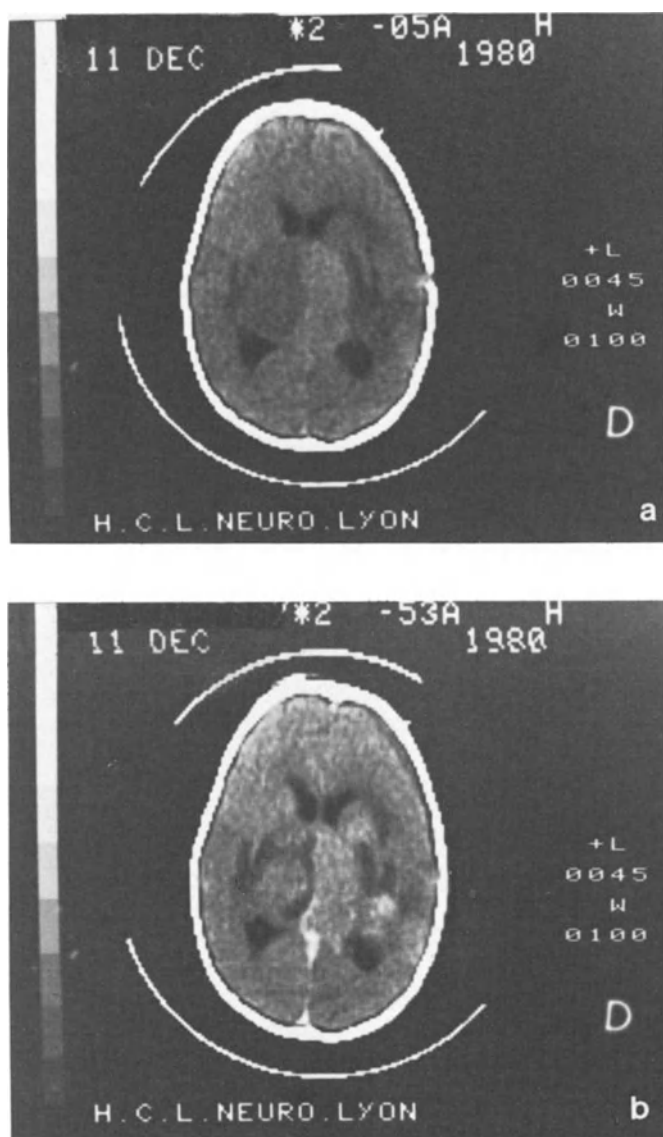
Intra-ventricular neuroblastoma. a) Pre-contrast CT. b) Post-contrast CT
